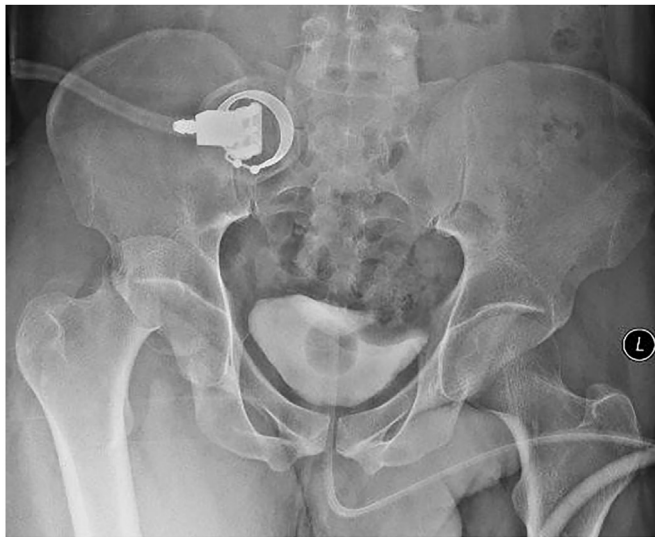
A. Anteroposterior radiograph of the pelvis demonstrating a posterior dislocation of the right hip and a femoral head fracture. The infrafoveal piece of the femoral head is retained in the acetabulum. B. Coronal CT demonstrating impaction, and perching of the femoral head on the edge of the acetabulum. C. Axial CT demonstrating perching of the femoral head on the edge of the acetabulum, and the retained infrafoveal of femoral head in the acetabulum.
